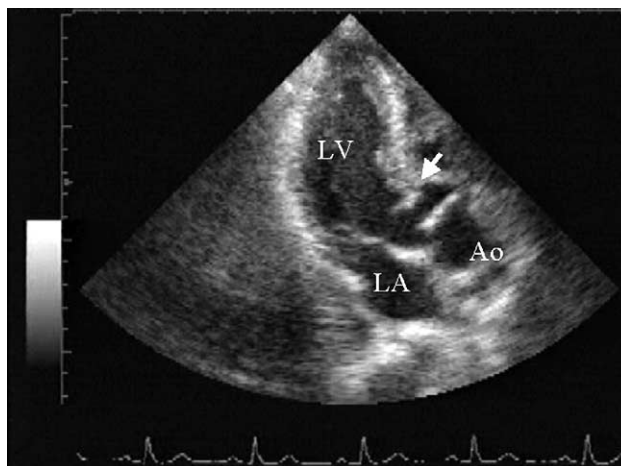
Transthoracic echocardiography revealed a 15-mm length of fixed subaortic obstruction (arrow) on the thickened interventricular septum at the left ventricular (LV) outflow tract. (Ao = aorta.)
